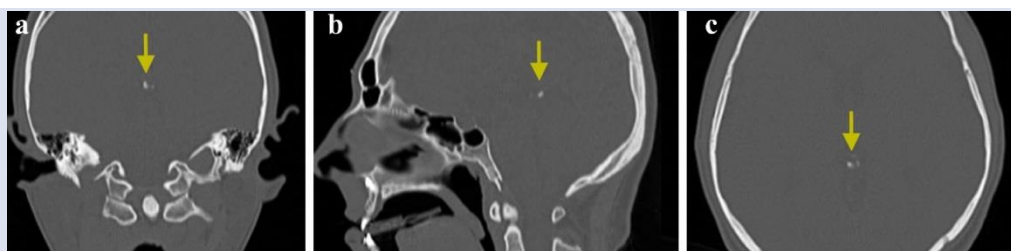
Coronal (a), sagittal (b), and axial (c) cone-beam computed tomography sections showing pineal gland calcification.
